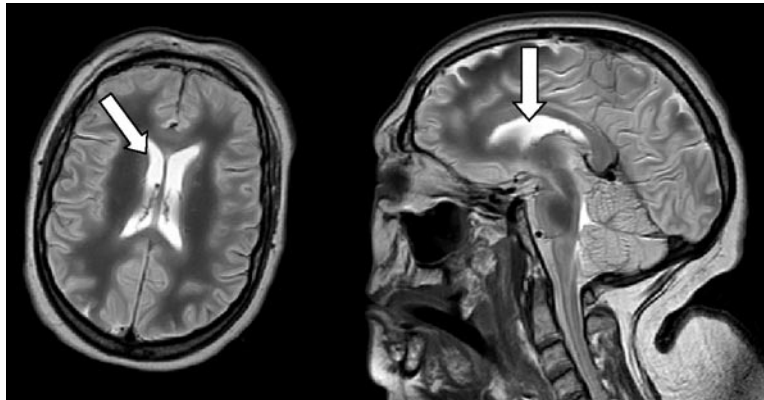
T1 weighted transverse and sagittal MRI images showing intraventricular and intracerebral gadolinium accumulation on day of admission.
